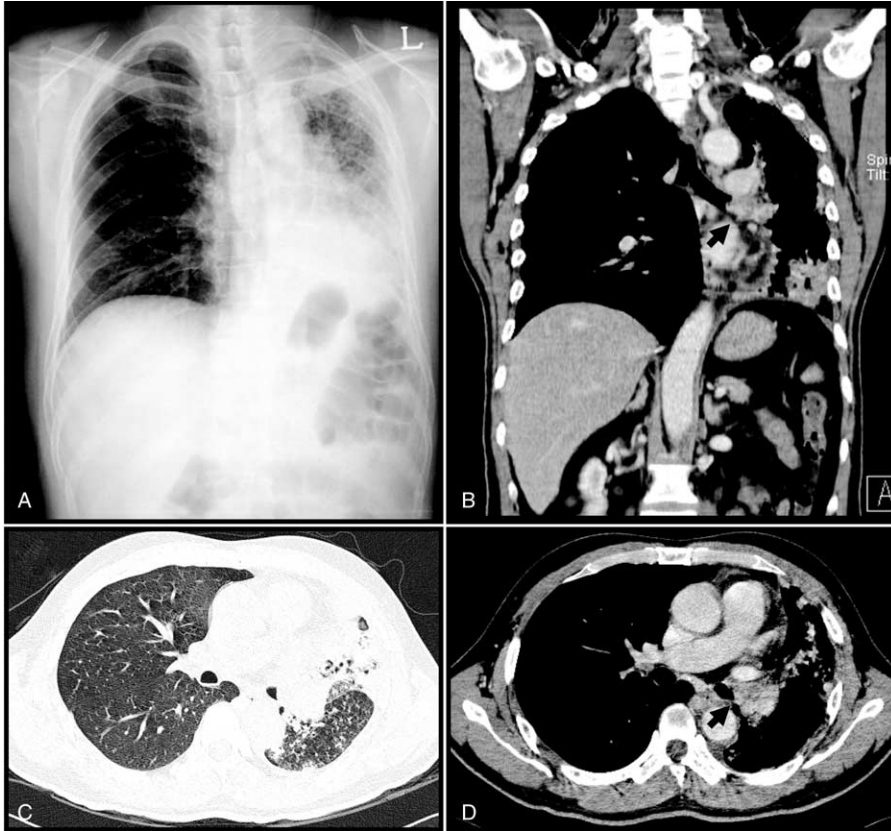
Chest radiograph (A) and CT scans (B, coronal view; C, lung setting view; D, mediastinal setting view) of the lung malignancy diagnosed initially 3 years ago. The radiologic images revealed an atelectasis of the left lung with pneumonic consolidation due to the heterogeneously enhanced lung mass on the left main bronchus. CT, computed tomography.
